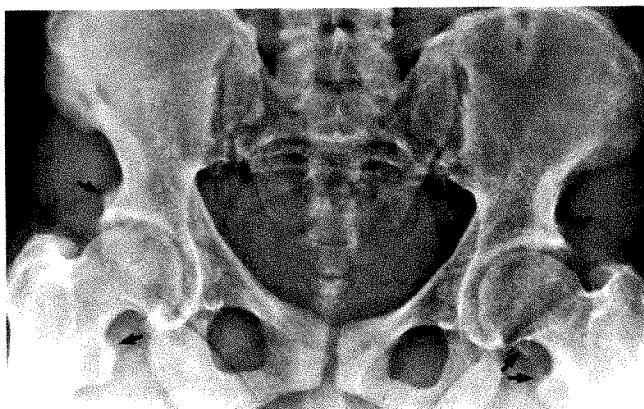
Radiograph shows symmetric widening of both fibrous and synovial parts of sacroiliac joints and bony proliferation about hips (arrows).
